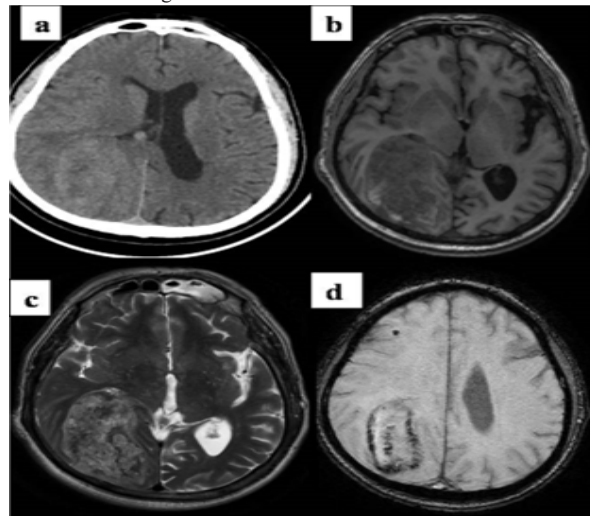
(a) CT brain shows an ill defined heterogeneously hyperdense
